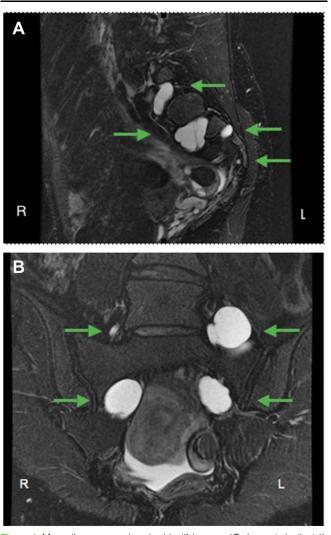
Magnetic resonance imaging identifying sacral Tarlov cysts (patient 1). (A) Sagittal view. Green arrows depict trilobed, multiseptate T2 hyperintense, T1 hypointense nonenhancing Tarlov perineurial cysts in the left L5-S1, left S1-S2, and left S2-S3 neural foramina (right S1-S2 cysts were also present and seen on other images). (B) Coronal view. Green arrows depict multiseptated T2 hyperintense, T1 hypointense perineurial cysts in the same patient. The largest cyst, at left L5-S1, tracks along the course of the L5 nerve root and measures 6 cm in greatest dimension.
